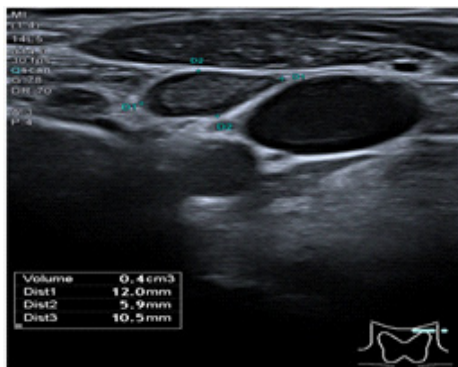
Ultrasound of the thyroid gland and parathyroid glands. The arrow shows an a small (size: 12 x 6 x 11 mm), ill defined, hypoechoic lesion posterior and cranial to the left thyroid lobe.
